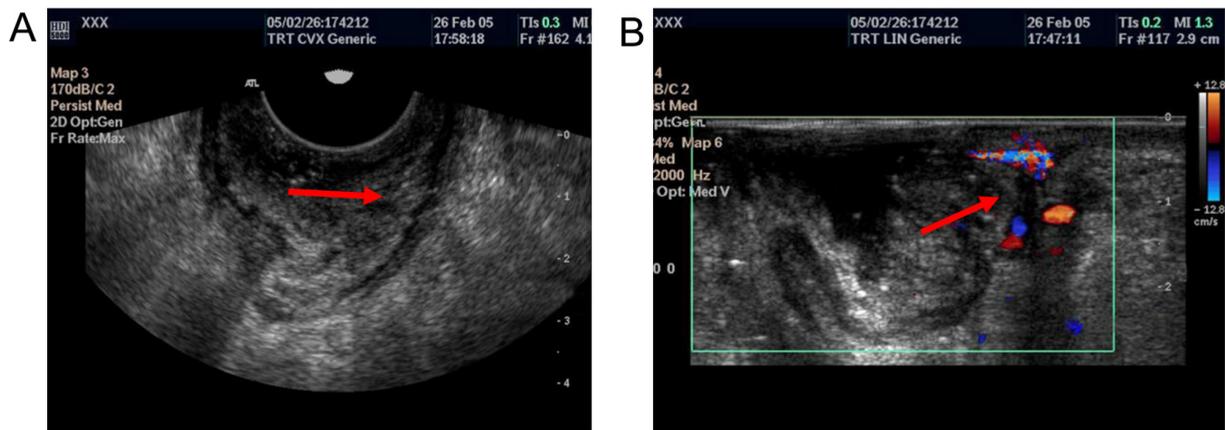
TRUS parameters of rectal cancer. A: Low-speed low-resistance arterial spectrum in rectal cancer (arrow); B: dotted blood flow signal in the tumor shown in color Doppler flow imaging (CDFI) (arrow).
